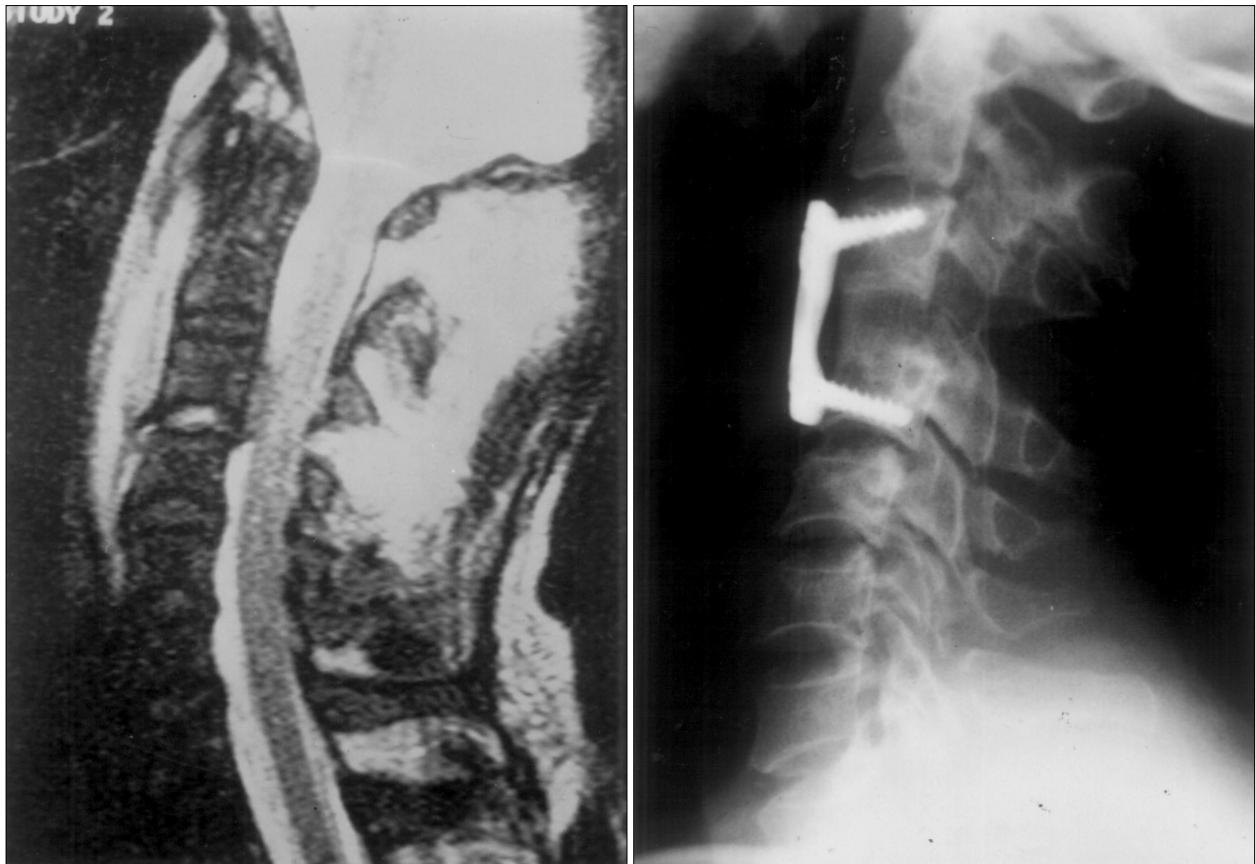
Magnetic resonance image and plain x-ray films obtained in a 52-year-old man with C3/4 flexion injury and Frankel grade D weakness after falling down(case 2). Left : preoperative MR image revealing spinal cord compression by intracanalicular ruptured disc particle and posterior interspinous disruption. Right : postoperative plain x-ray film shows stable intervertebral bony fusion. The patient improved to Frankel Grade E after removal of ruptured disc particle.
